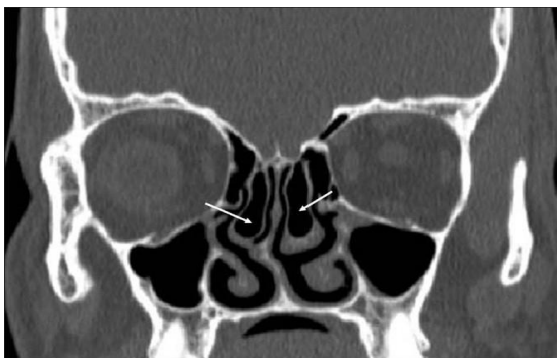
Coronal CT slice showed concha bullosa(arrow)
